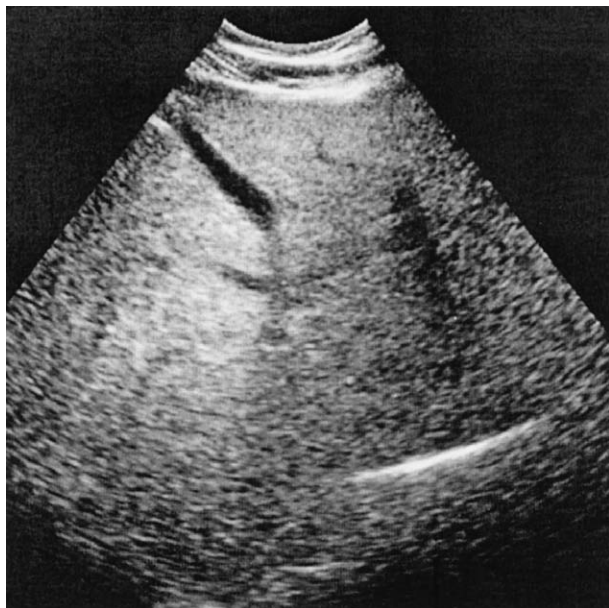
Ultrasound showing a diffuse liver lesion.
